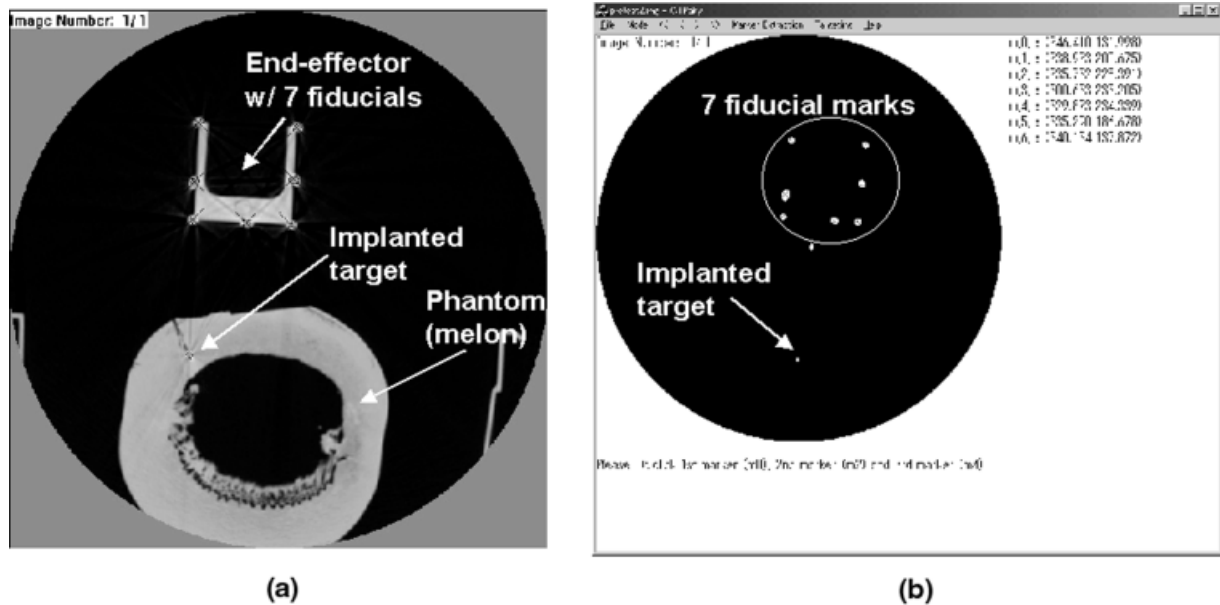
CT image with the end-effector frame and target point, as seen on the scanner's console (a) and as seen in the treatment planning software after binary thresholding (b).
